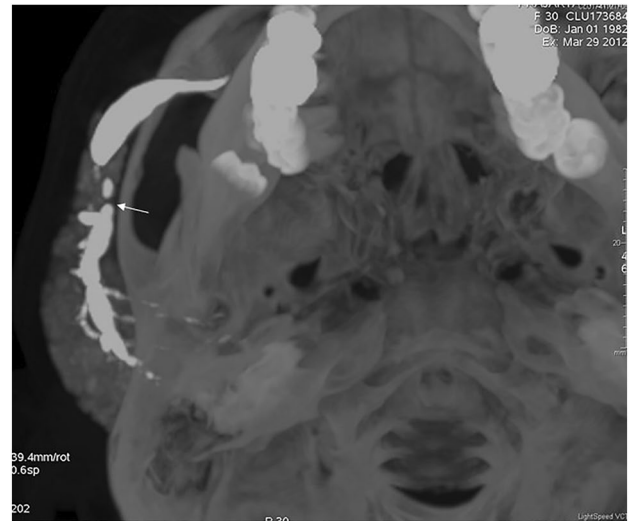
Axial CT sialogram demonstrates minimal calcified sialolith presenting as partial filling defect/void in right parotid duct
